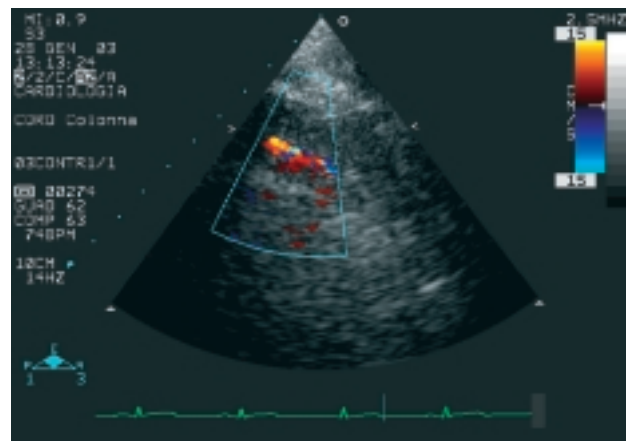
Apical 2-chamber view visualizing the distal portion of the left anterior descending coronary artery. The vessel is close to the anterior wall of the left ventricle, in the interventricular sulcus. The color Doppler shows the vessel in red; the color Doppler scale is very sensitive for low velocities.
